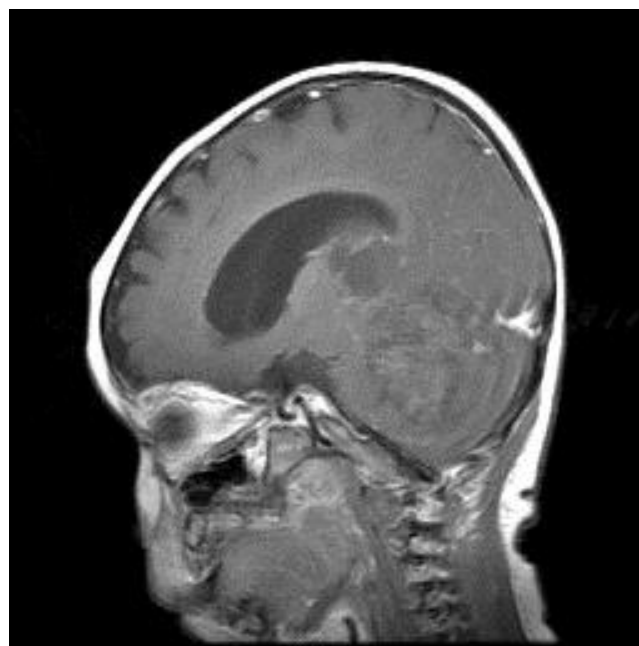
A contrast-enhanced T1-weighted magnetic resonance image showing a 5.6-cm×5.0-cm×7.6-cm heterogeneous mass with intratumoral hemorrhage in the cerebellar vermis and associated hydrocephalus.
